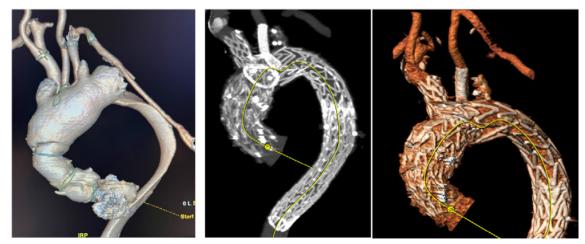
Pre- and postoperative (at 2 years) computed tomography angiography with 3D reconstruction.
